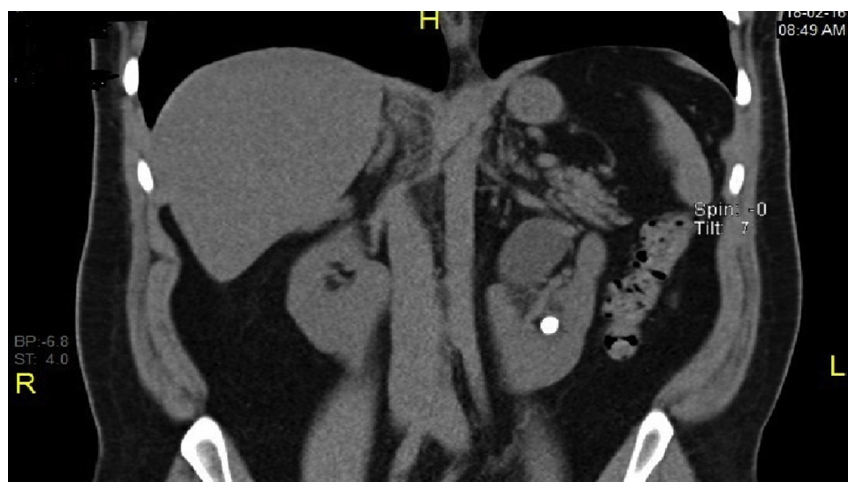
CT KUB, middle calyx stone.
